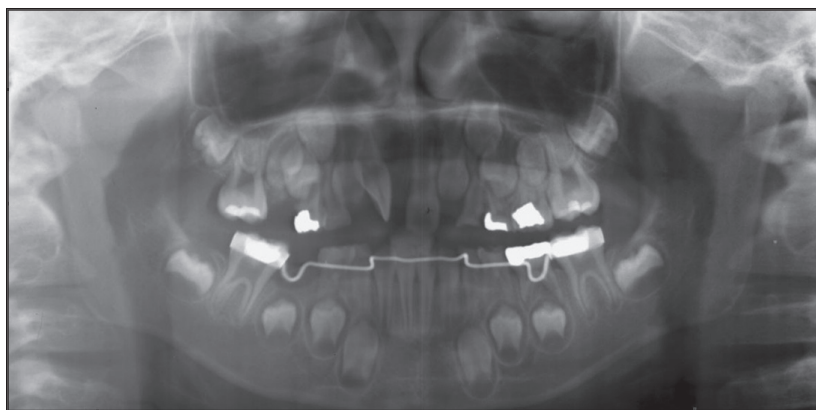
Panoramic radiograph of an 8-year-old patient after removing the supernumerary tooth and the cyst surrounding its crown.
